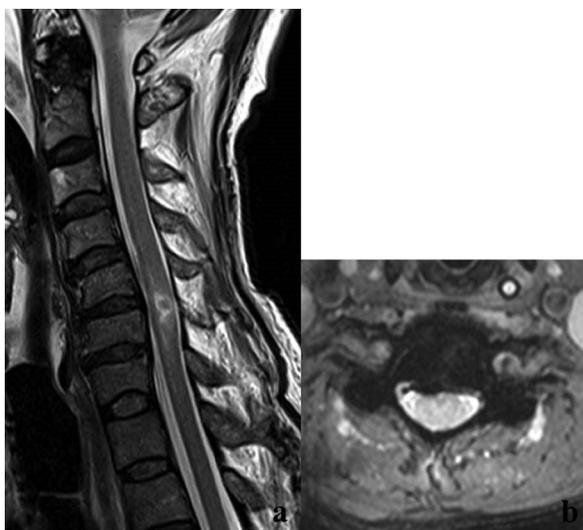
(a and b) Hyperflexion trauma with spinal cord contusion. Midsagittal FSE T2-weighted MR image (a) depicting spinal cord edema spanning over two segments a C5-C6 centered by a little hypointense spot of hemorrhage (Bondurant grade 4 lesion) [68]. On axial GRE-T2*-weighted scan (b), the edema does involve the entire cross section of cord with little hypointense spots inside (Basic grade 4) [76].
